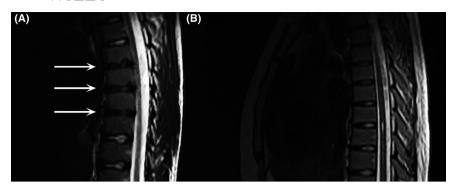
Zoomed view MRI T2weighted sagittal images of the thoracic spine. (A) Football (soccer) player with reduced disk signal and height at three levels (arrows). (B) Non-athlete without significant changes
